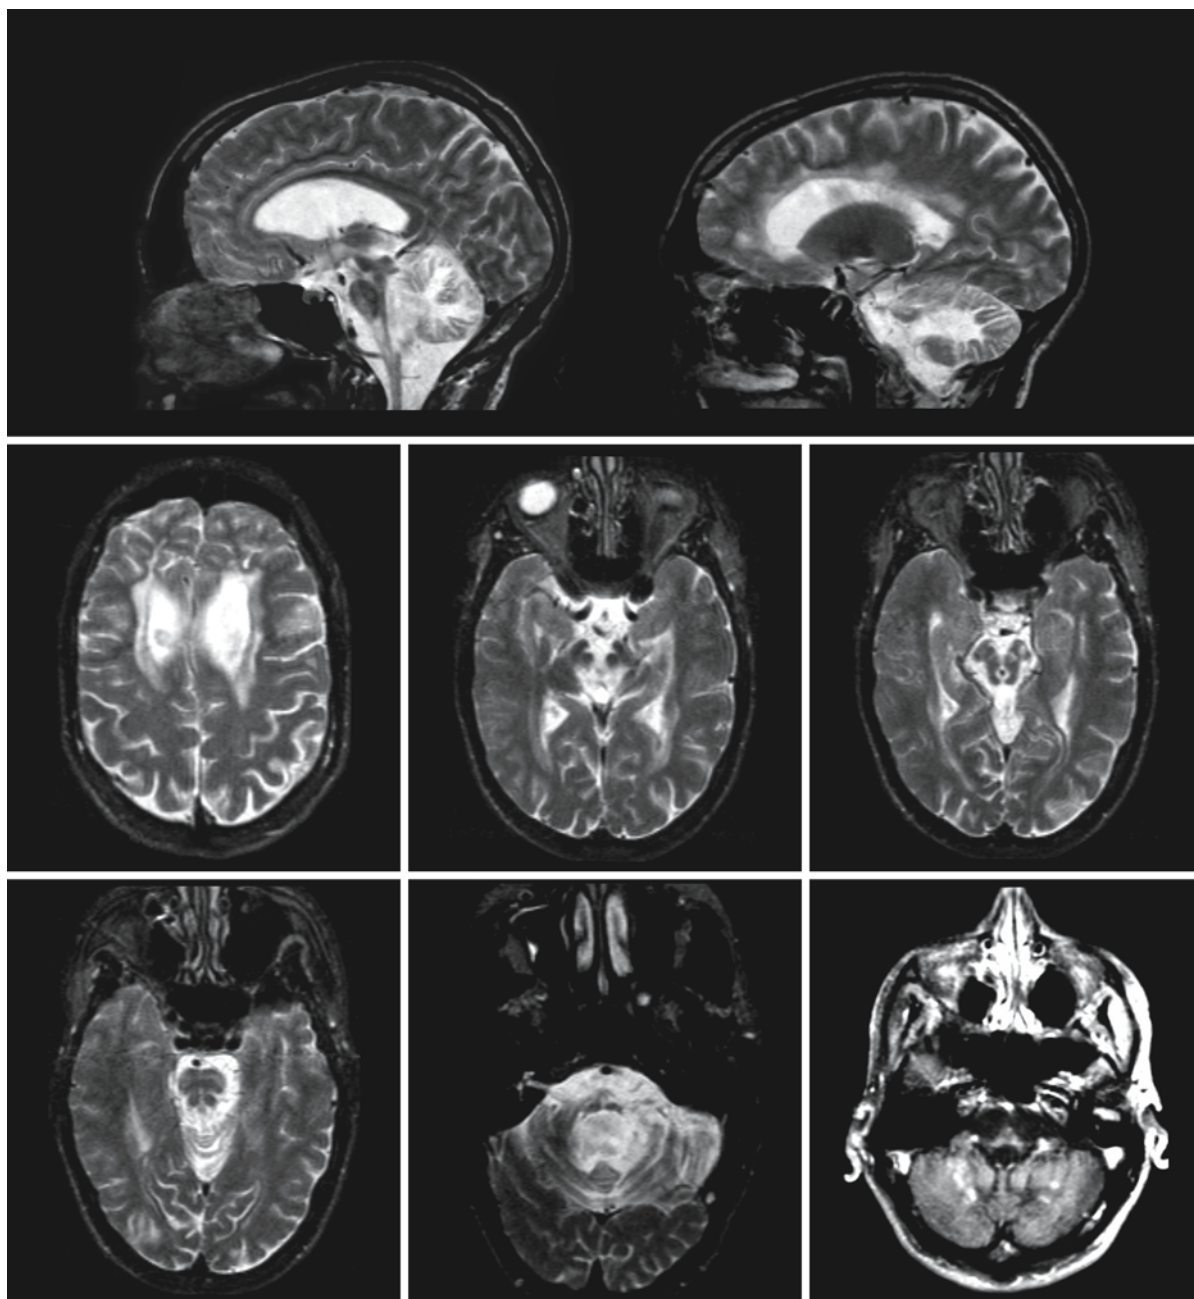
A 32-year-old patient with adult AD. He had a slowly progressive neurological course and died soon after the MRI. Numerous Rosenthal fibers were found at autopsy and a mutation in the *GFAP* gene was found, not present in his mother (father not investigated). Most prominent features are
